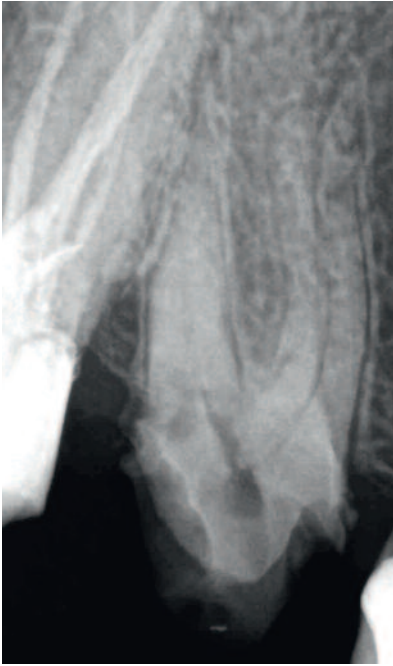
Radiograph taken immediately after caries removal, showing close proximity of the cavity walls to the pulp, especially at the distal abutment wall
